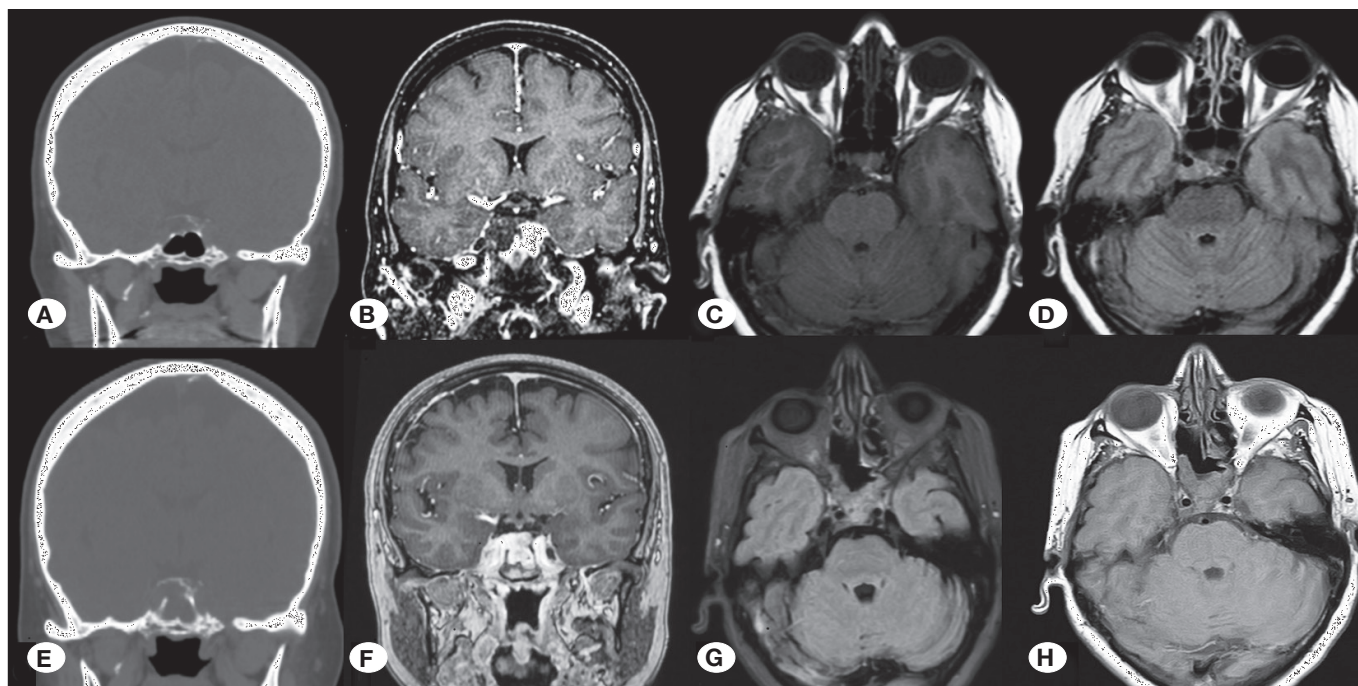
Preoperative and postoperative radiological evaluation. Preoperative CT scan (A) showed the lysis of the right half of the dorsum sellae, with loss of cortical bone continuity in the superior-right margin of the upper clivus. Preoperative MRI showed a contrast-enhanced mass (B), homogeneously hypointense in T1-W images (C), partially suppressed in T2 FLAIR (D), with ADC values higher than the brain parenchyma. A mass effect on the right side of the pituitary gland and on the posterior knee of the right cavernous internal carotid artery (C4), with inferior extension to the middle third of the clivus, was observed. Postoperative CT (E) and magnetic resonance imaging (MRI) (F, G, H) showed complete excision of the neof ormation with no sign of complications or recurrence.
